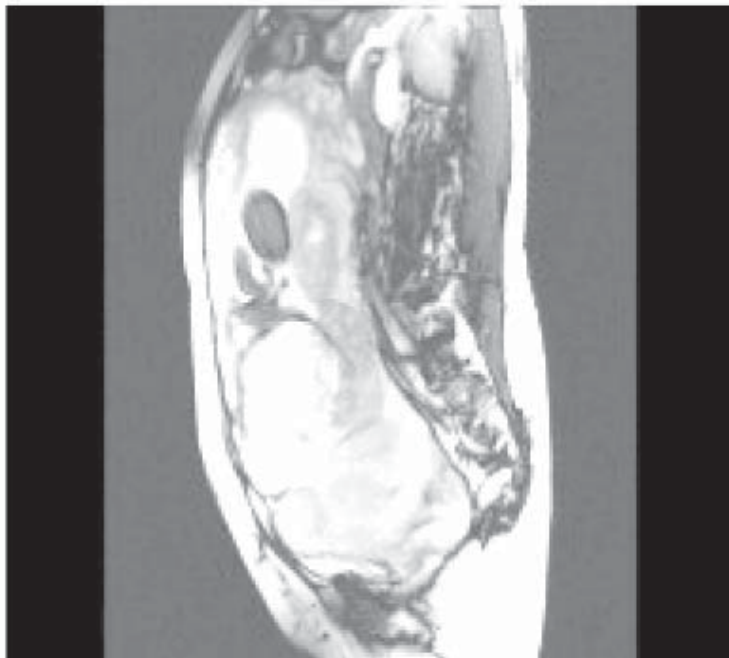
MRI-Sagittal view showing loss of hypointensity between placenta and bladder
